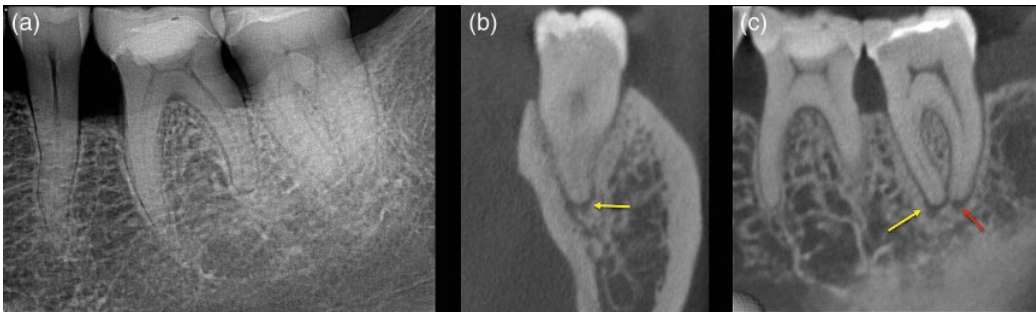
Apical periodontitis. (a) Radiograph of lower left quadrant in patient with poorly localized symptoms of irreversible pulpitis. (b, c) coronal and sagittal reconstructed CBCT views confirm a periapical radiolucency associated with the mesial (yellow arrow) and distal (red arrow) roots of the lower left second molar tooth.
